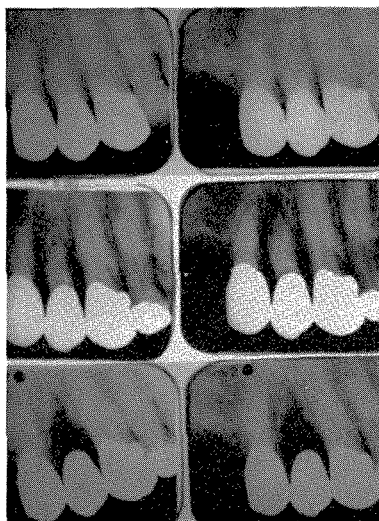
Roentgenograms before and after of the case shown in Figs. 442 and 443. Top, Insertion of the splint. Middle, Caries has attacked the first bicuspid. Bottom, The bicuspid has been removed. The splint is still in place.
